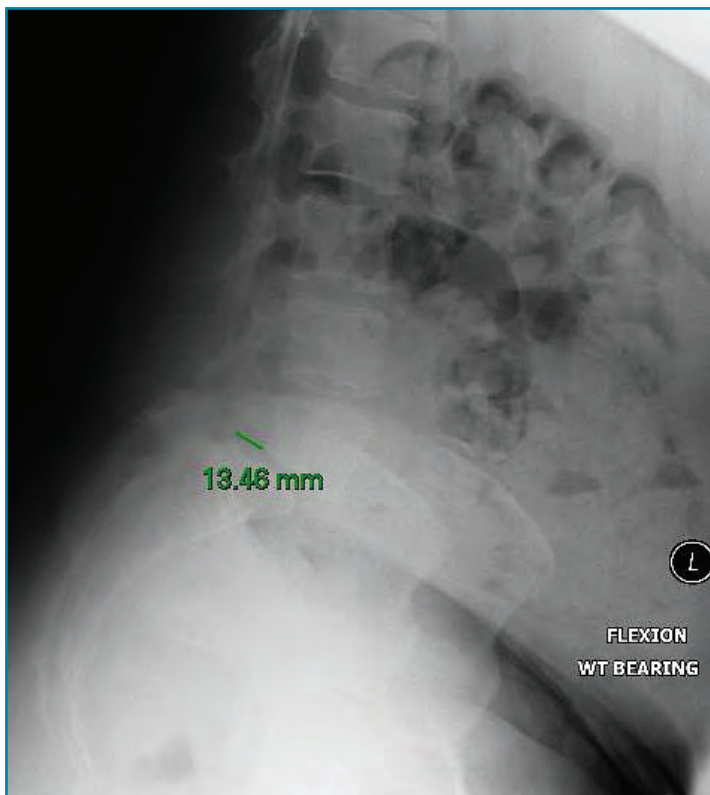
Flexion with measurement x-ray.
